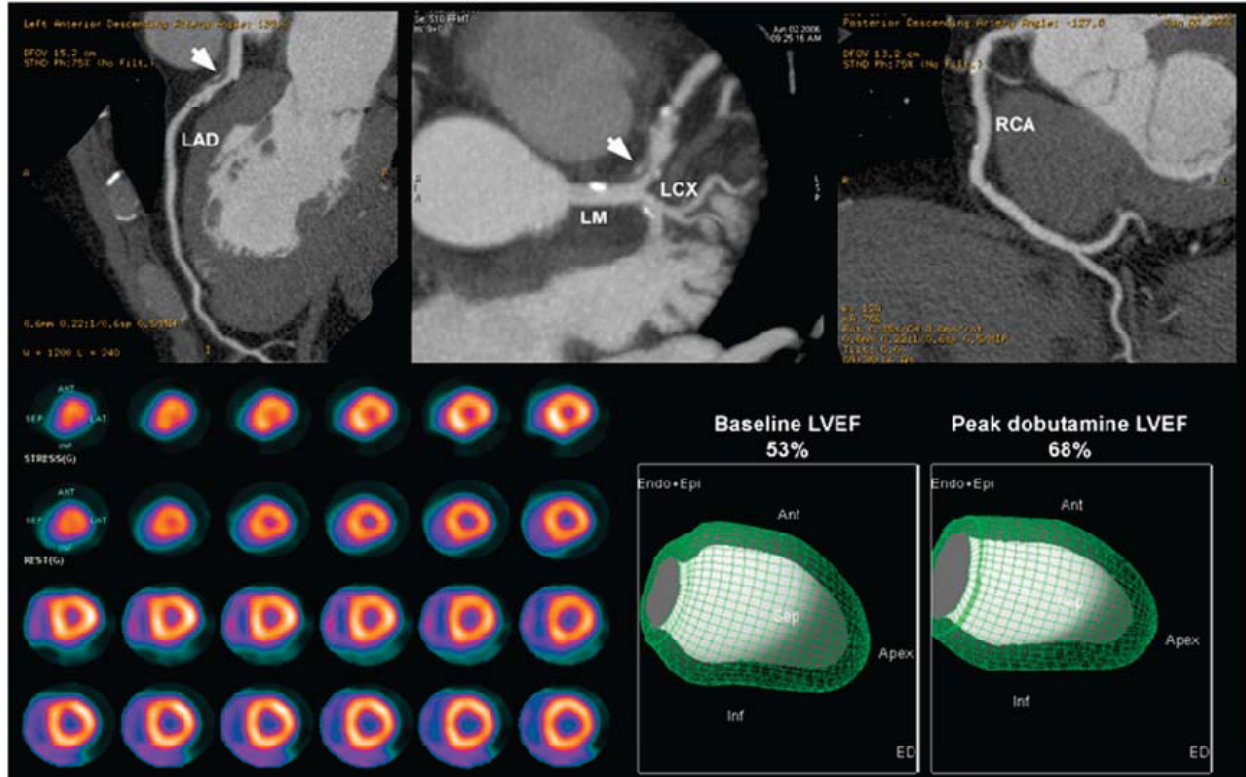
Integrated PET/CTA study. CTA images demonstrate noncalcified plaque (arrow) in proximal LAD with 50%–70% stenosis. However, rest and peak dobutamine stress myocardial perfusion PET study (bottom left panel) demonstrates only minimal inferoapical ischemia. In addition, LVEF was normal at rest and demonstrated a normal rise during peak dobutamine stress. LAD 5 left anterior descending coronary artery; LCX 5 left circumflex coronary artery; LM 5 left main coronary artery; RCA 5 right coronary artery; Ant 5 anterior; Inf 5 inferior. (Reprinted with permission of (28).)
